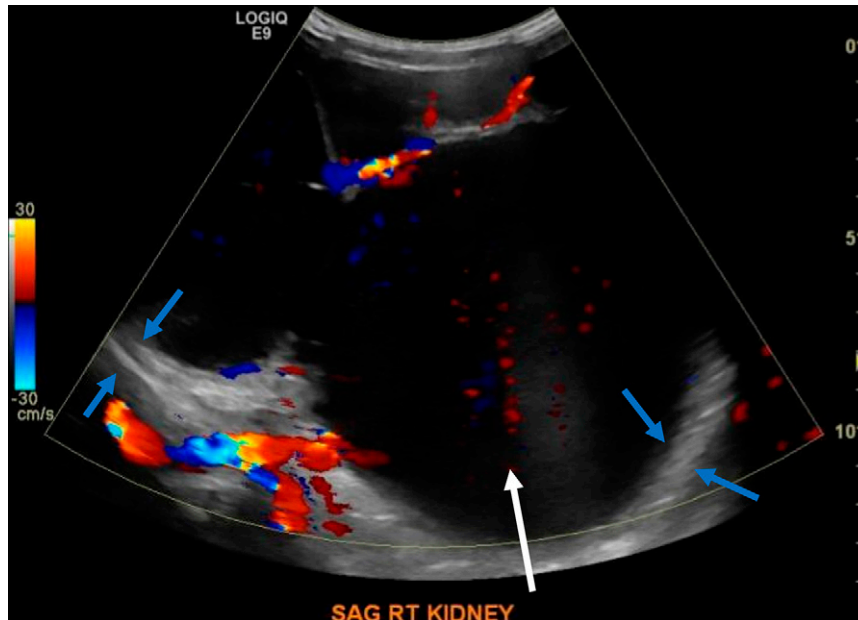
The patient's abdominal ultrasound showing massive pelvocaliectasis of the right kidney. The white arrow indicates the massively dilated central collecting system surrounded by thinned kidney parenchyma, indicated by blue arrows in two areas. Sag, sagittal; Rt, right.
